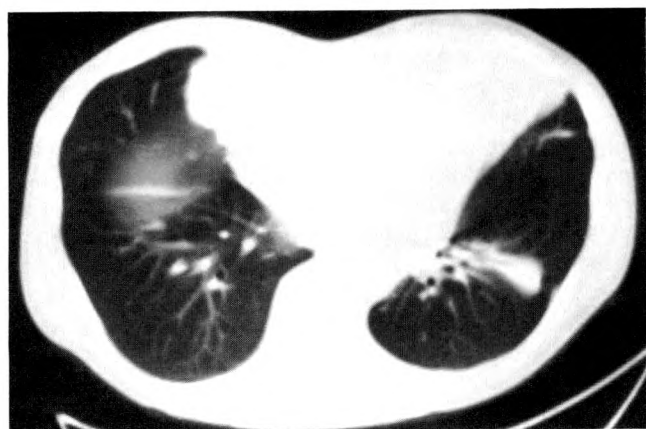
CT scan through lower lobes in patient with non-Hodgkin's lymphoma. In the left lower lobe, fusiform mass of lymphoma surrounds bronchovascular bundle leaving bronchus patent. At autopsy, epicardial masses also proved to be lymphoma.
